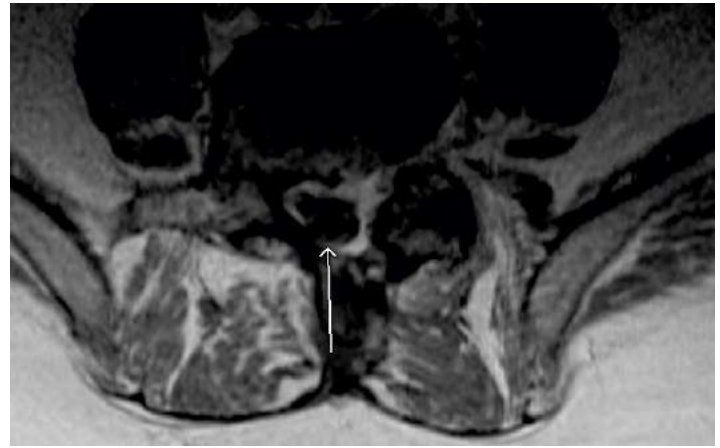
Axial post-contrast T1 MRI with lumbar nerve root enhancement at L5
